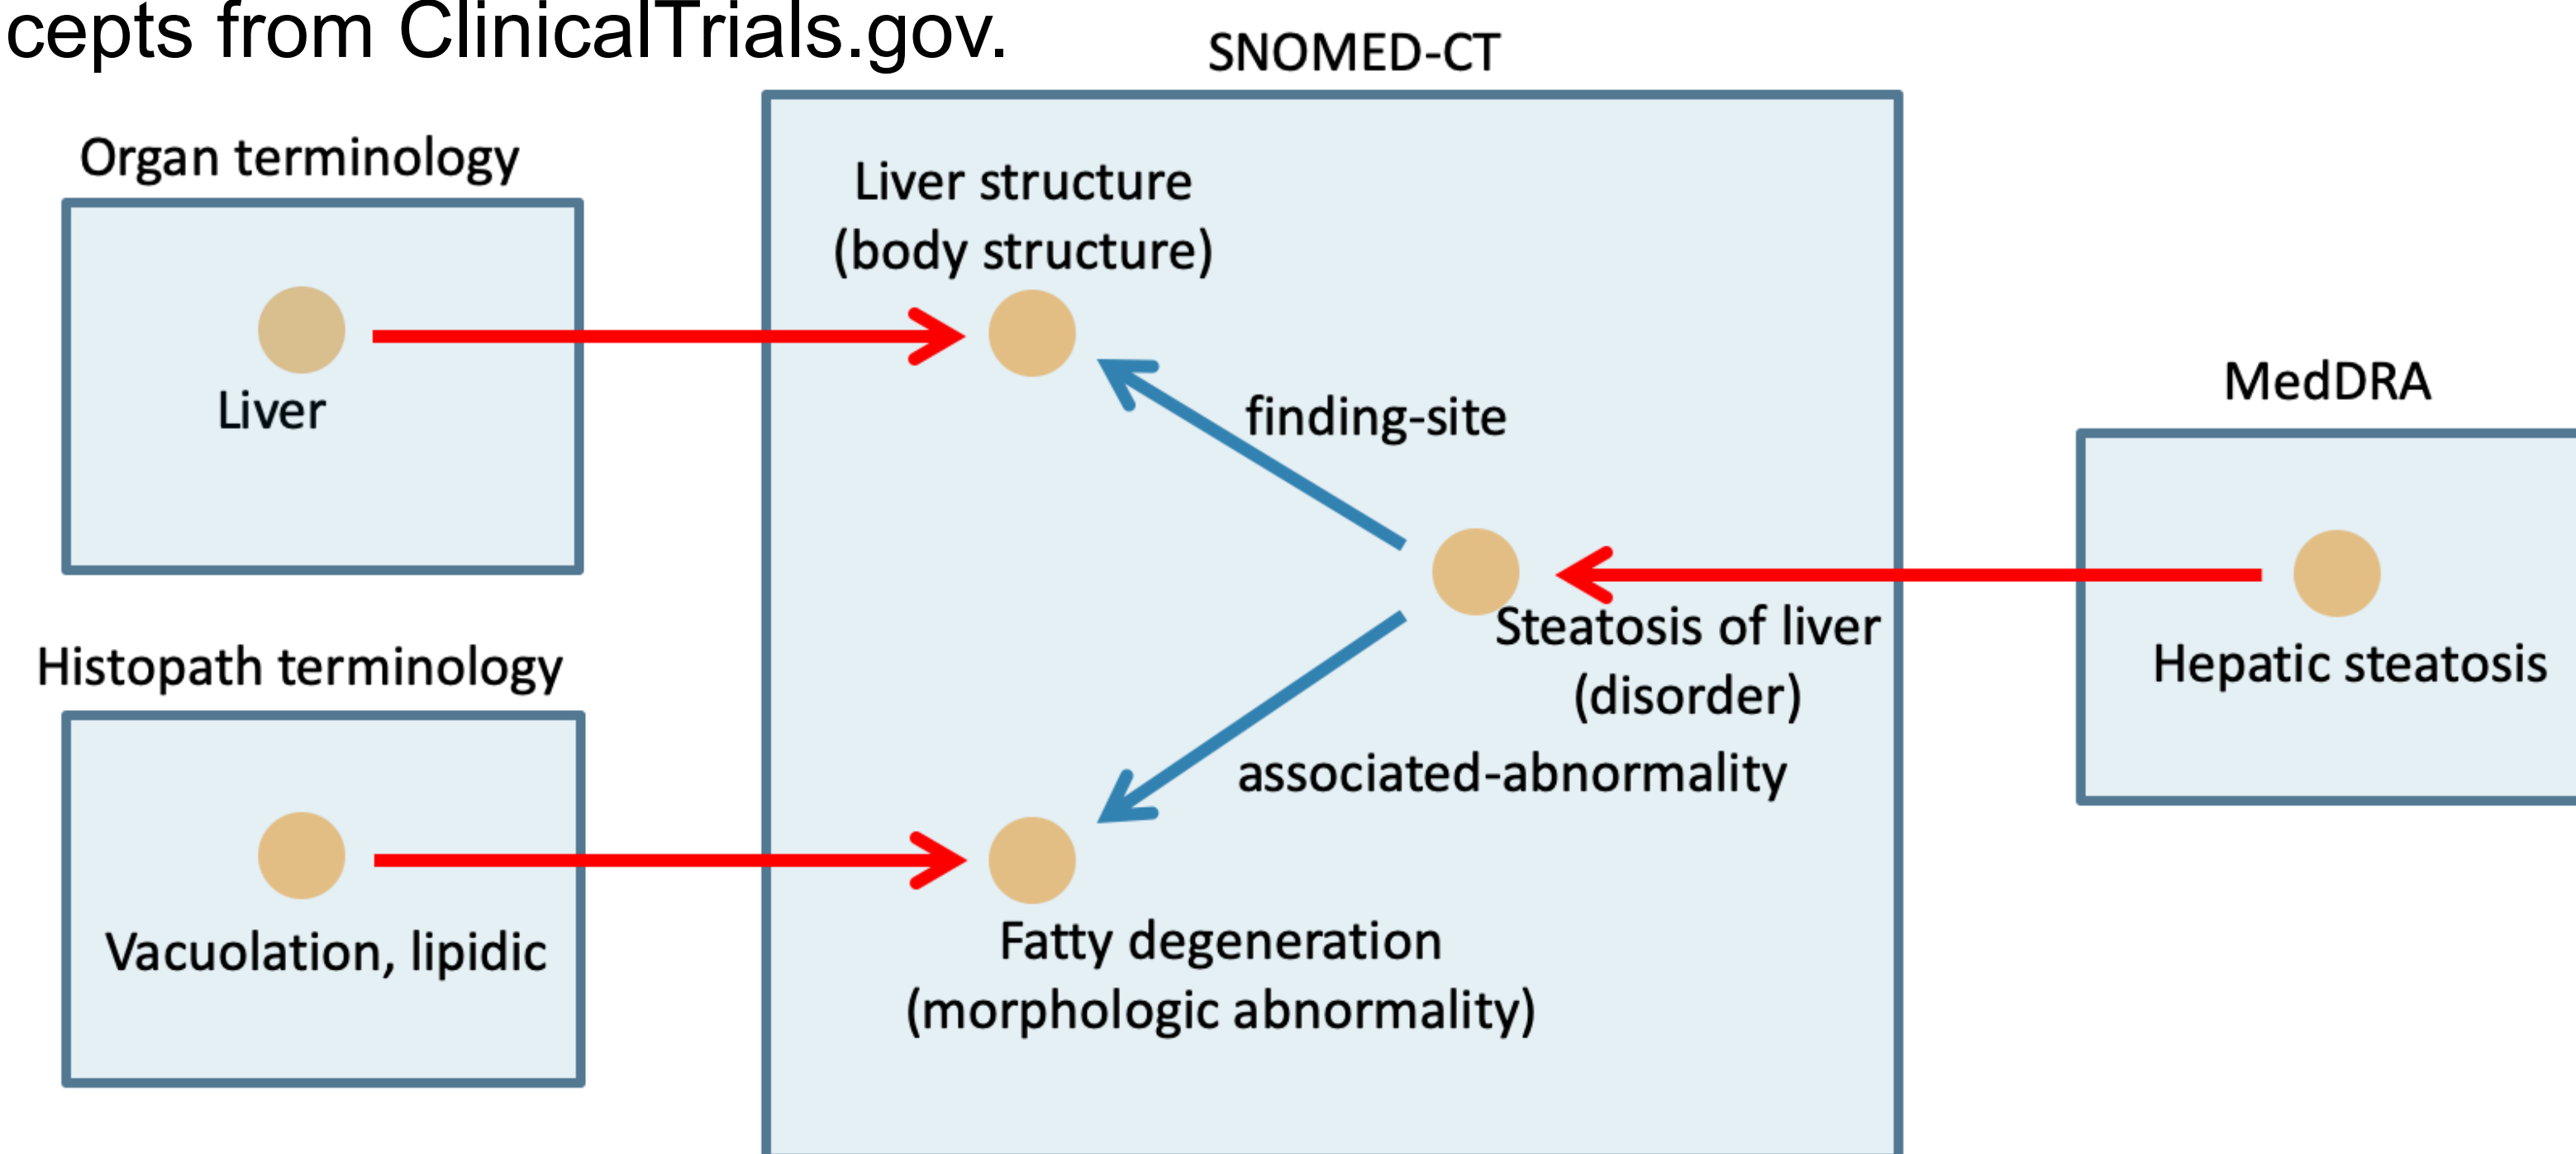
Mapping using SNOMED-CT as intermediary terminology
